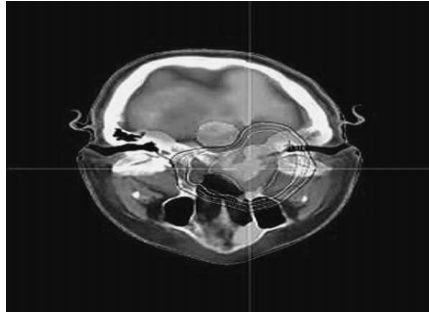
Fused CT/PET image showing radiation iso-dose lines around a nasal tumor.
